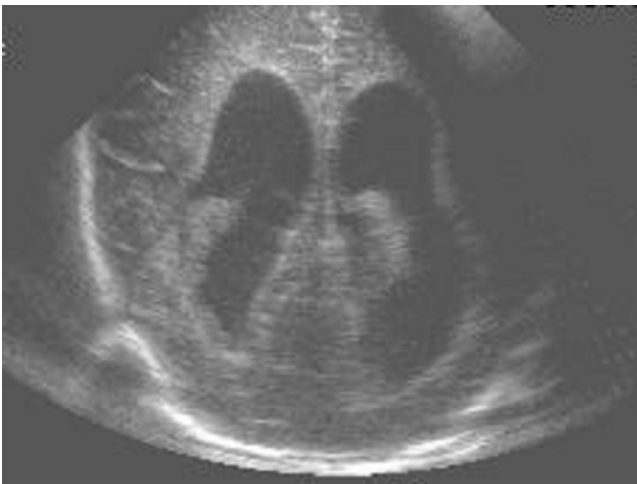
Brain ultrasonography on 18th hospital day shows dilation of ventricle (patient 1).
